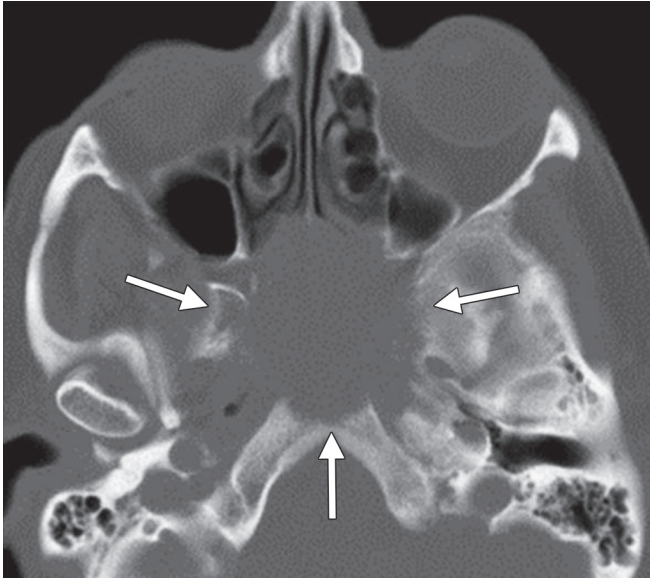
Osseous erosion. Axial CT demonstrates a sphenoid sinus lesion eroding the clivus. Note the margin is irregular and infiltrative (arrows), highly suggestive of an aggressive tumor.
